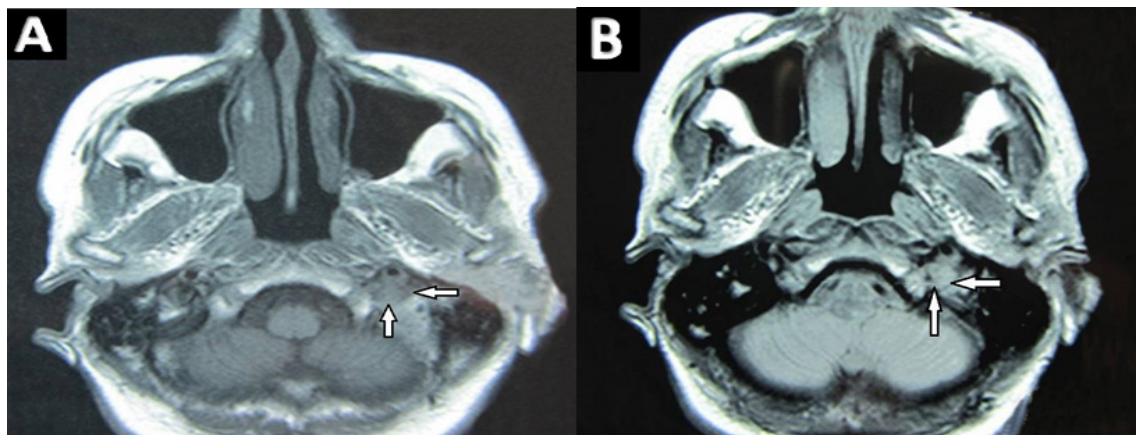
A and B: Follow-up brain MRI on T1W and fluid-attenuated inversion recovery respectively after one year, show reduced size (16×10×8mm) of extra-axial mass within the left jugular foramen (thick white arrows).
